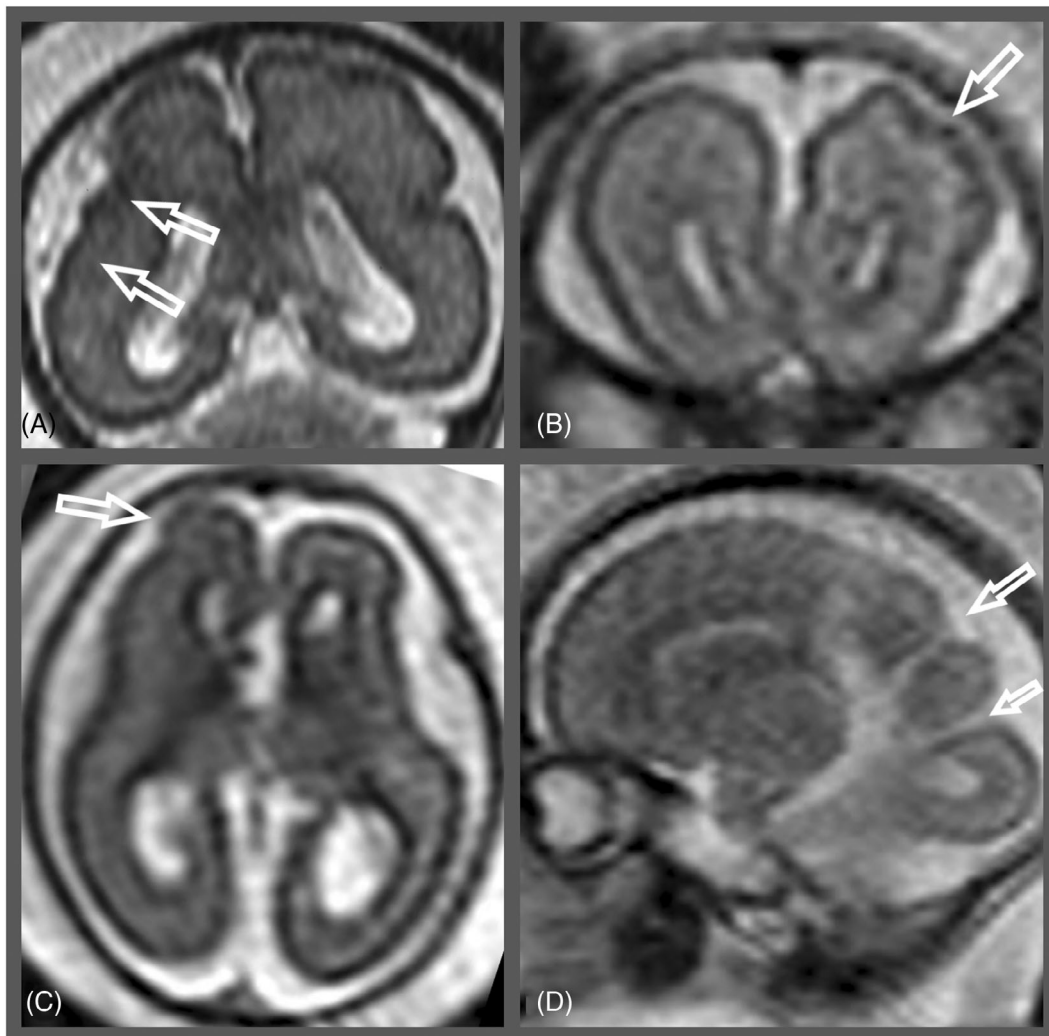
Polymicrogyria: different early cortical patterns. (A) coronal T2-weighted image in a 22 GW fetus showing the “sawtooth” appearance (arrows); (B) coronal T2-weighted image in a 22 GW fetus with the “wartlike” pattern (arrow); (C) axial T2-weighted image in a 21 GW fetus showing focal bump in the right frontal lobe (arrow); (D) sagittal T2-weighted image in a 21 GW fetus showing abnormal sulci (arrows) in the parieto-occipital region
